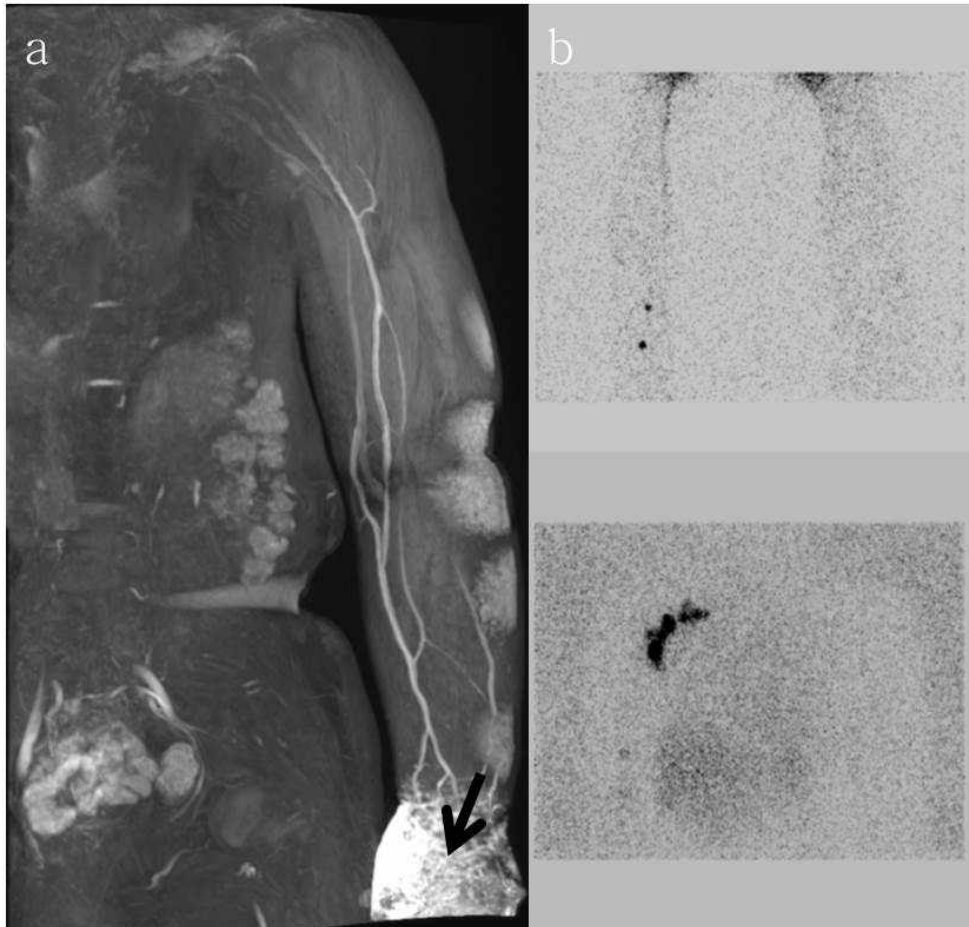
Comparison of demonstration of lymph nodes in a 71-year-old patient with stage II lymphedema on the left side. (a) MR lymphangiography image shows no depiction of axillary lymph nodes after 10 minutes of gadobutrol injection. Dermal backflow with beaded appearance of lymph vessels (black arrow) are prominent at left hand. (b) Lymphoscintigraphy image also demonstrates no lymph node at the ipsilateral axilla after 90 minutes of radioactive tracer injection. Note the lymph nodes at axilla and elbow of the unaffected side.
